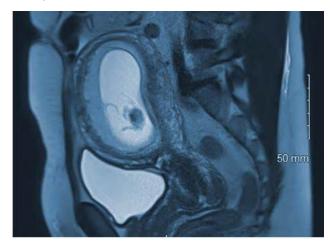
Sagittal view of T2 weighted MRI without contrast showing IUP at approximately 10 weeks gestation.
